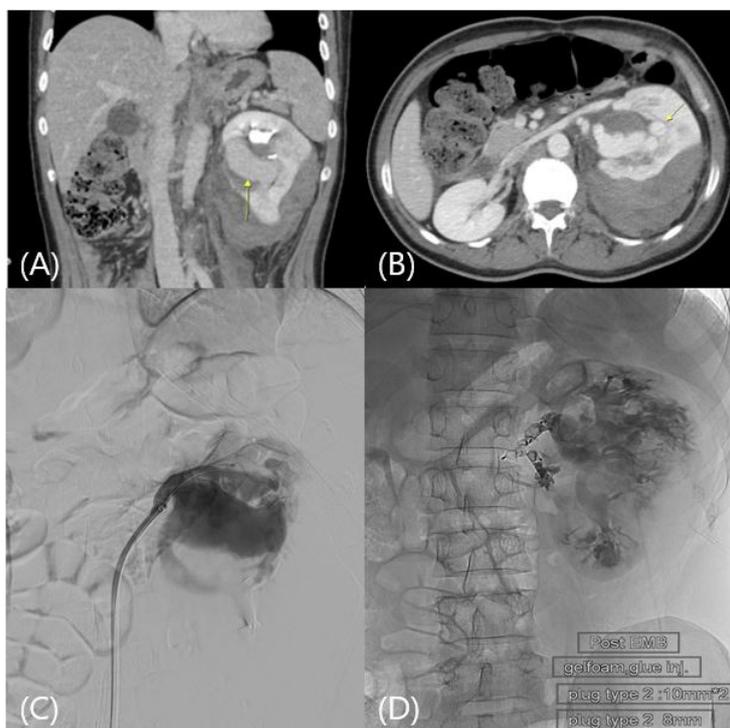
Computed tomography(CT) : grade IV left kidney injury with large perirenal and subcapsular hematoma (A) Coronal view and (B) horizontal view. Angiographic Confirmation of kidney artery pseudoaneurysm (C) and result after embolization (D).
